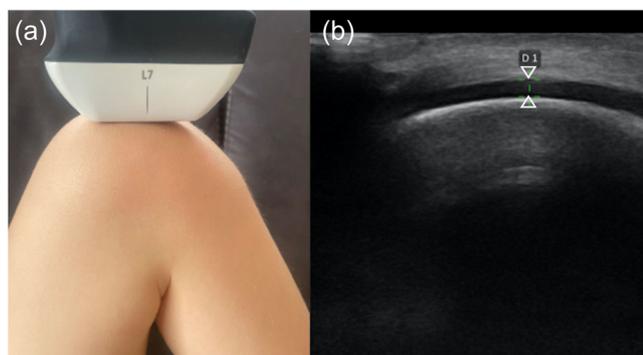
Imaging methodology of the medial femoral condyle cartilage. (a) Clarius L7 BW Scanner transducer position on the dominant leg. (b) Ultrasound image of the medial femoral condyle cartilage in adolescents. Arrowheads mark measurement points for thickness determination.
